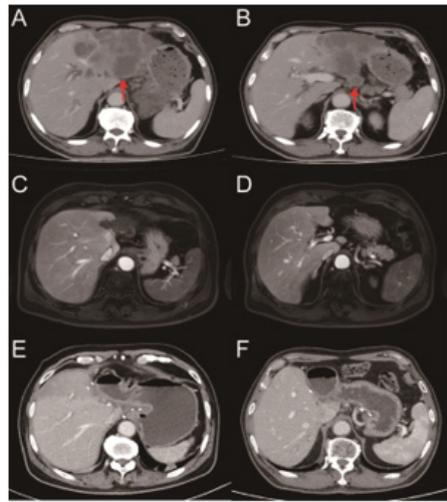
Serial computed tomography imaging assessments during conversion therapy. (A, B), baseline imaging in September 2022. The red arrows indicate the primary liver tumor and the enlarged lymph nodes at the hepatic hilum. (C, D), preoperative imaging in May 2024. (E), postoperative imaging in June 2024. (F), latest follow-up imaging in December 2025.
